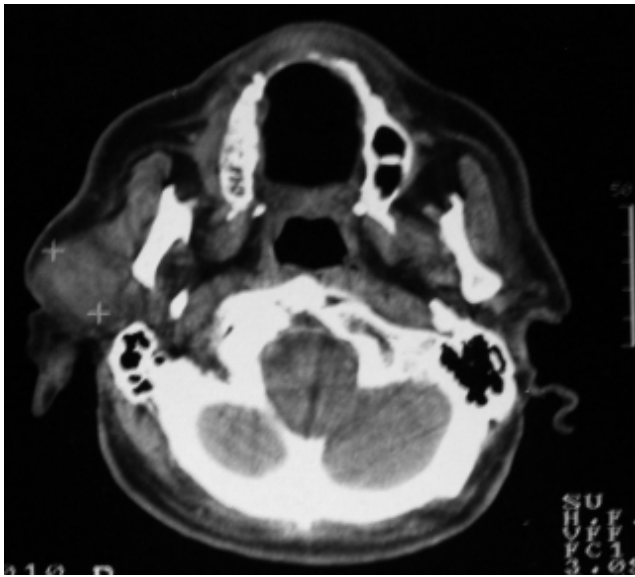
Preoperative CT scan showing a right parotid mass
